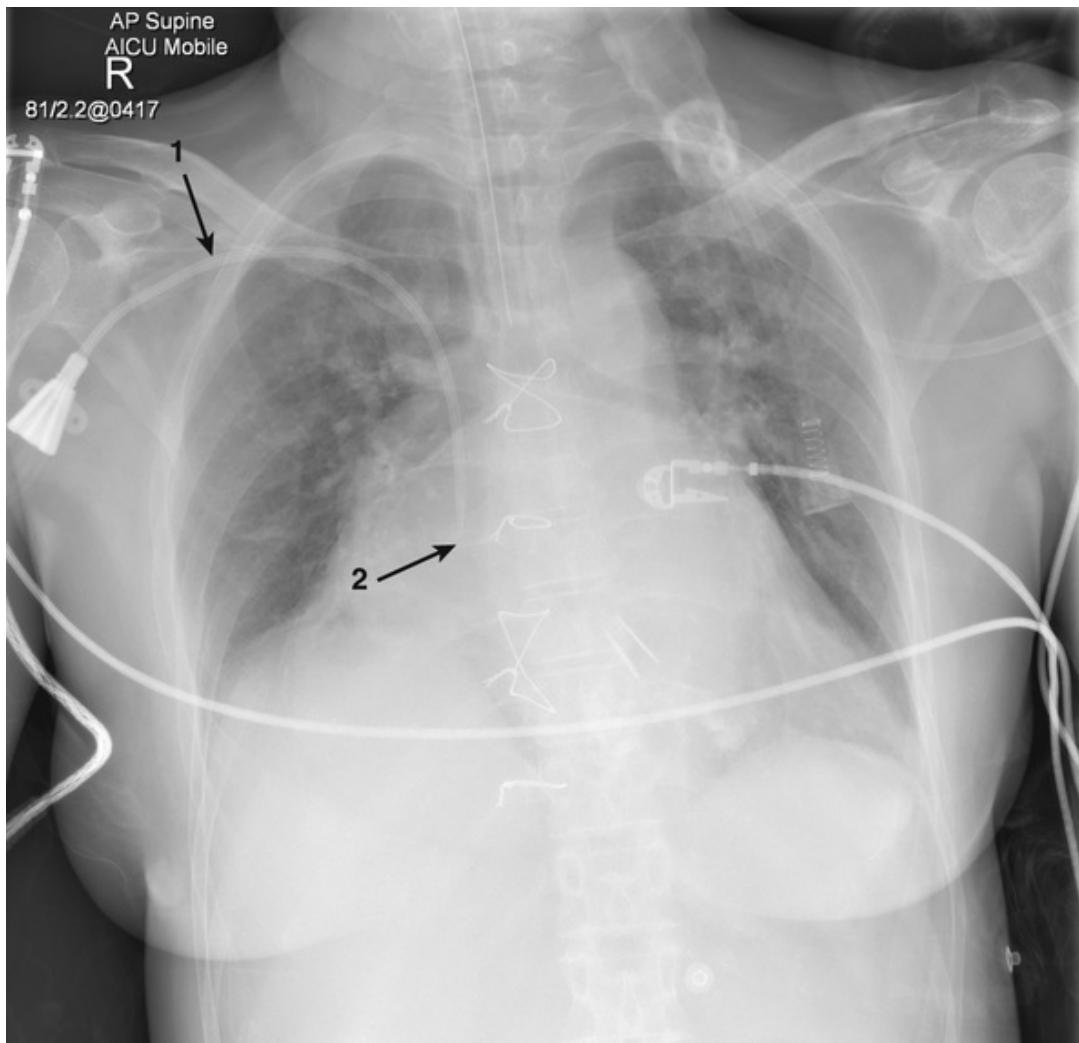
In this x-ray the central line has been introduced through the right subclavian vein (1) and follows the course of the subclavian through to the right brachiocephalic vein. The tip can be seen in the superior vena cava (2).
